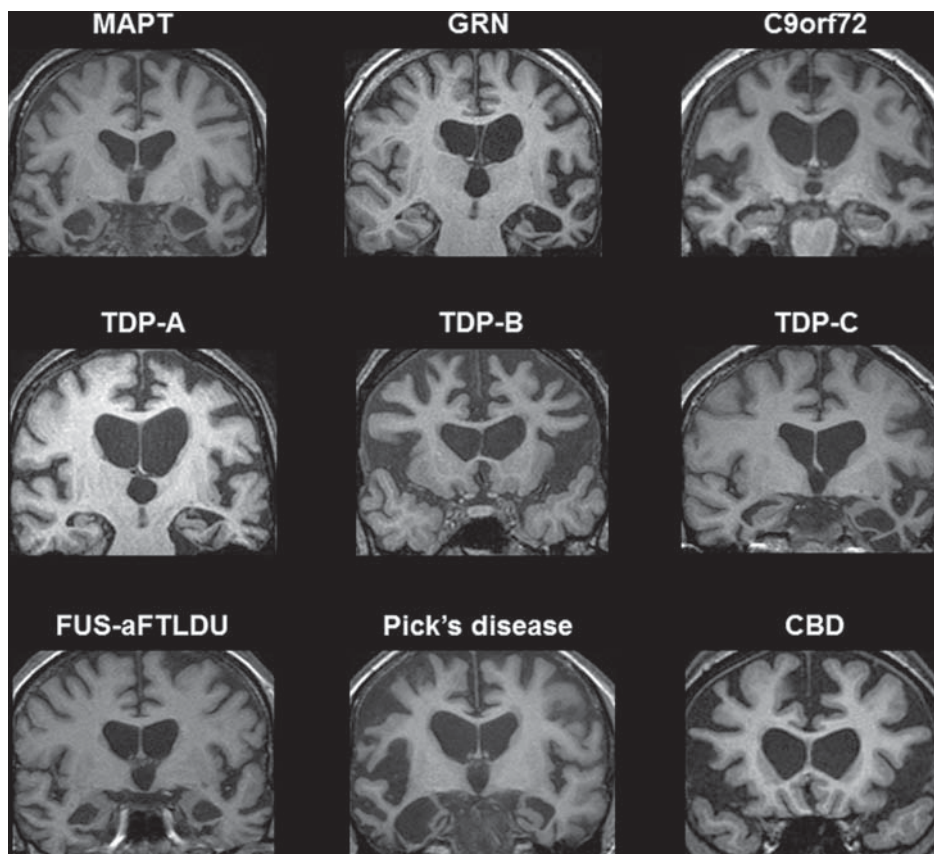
Coronal T1 MR images showing examples of patterns of grey matter atrophy in genetically and pathologically defined frontotemporal dementia. In MAPT mutations there is relatively symmetrical medial temporal atrophy; in GRN mutations there is asymmetrical temporo-fronto-parietal atrophy (affecting the left hemisphere here but can affect either hemisphere); in C9ORF72 expansions there is relatively symmetrical fronto-temporal atrophy. In TDP-A pathology there is asymmetrical temporo-fronto-parietal atrophy (here left-sided predominant but can affect either hemisphere). In TDP-B pathology there is more symmetrical atrophy affecting the frontal lobe, insula and anteromedial temporal lobe. In TDP-C pathology there is asymmetrical anteroinferior temporal lobe atrophy (here left-sided predominant but can affect either hemisphere). In FUS pathology there is caudate and anterior temporal lobe atrophy (and also orbitofrontal lobe and anterior cingulate involvement). In Pick's disease there is asymmetrical fronto-insula-temporal atrophy (here right-sided predominant but can affect either hemisphere); in CBD there is fronto-parietal atrophy.
